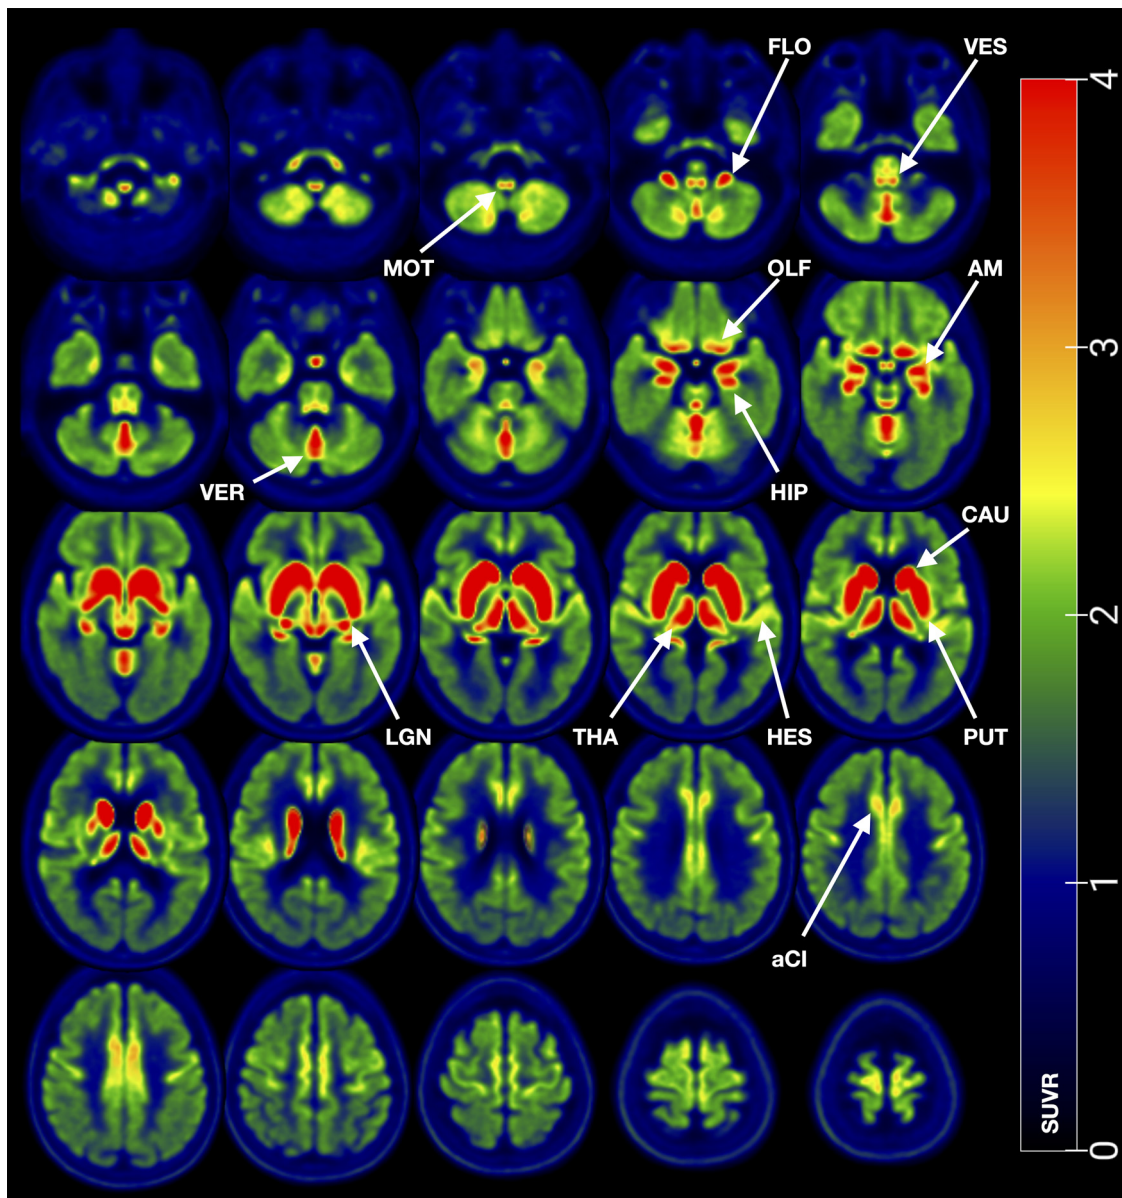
Averaged axial slices of healthy elderly human brains imaged with [^{18}F]FEOBV PET. The [^{18}F]FEOBV PET image volumes are displayed in a mosaic of axial slices from the obex of the medulla oblongata to the vertex cranii. aCI, anterior cingulate; AM, amygdala; CAU, caudate; HIP, hippocampus; HES, Heschl's gyrus; LGN, lateral geniculate nucleus; MOT, dorsal motor nucleus of the vagus and hypoglossus nucleus; OLF, olfactory cortex; PUT, putamen; THA, thalamus; VER, vermis; VES, vestibular nucleus complex. Red colour indicates SUVR of 4 or higher.
